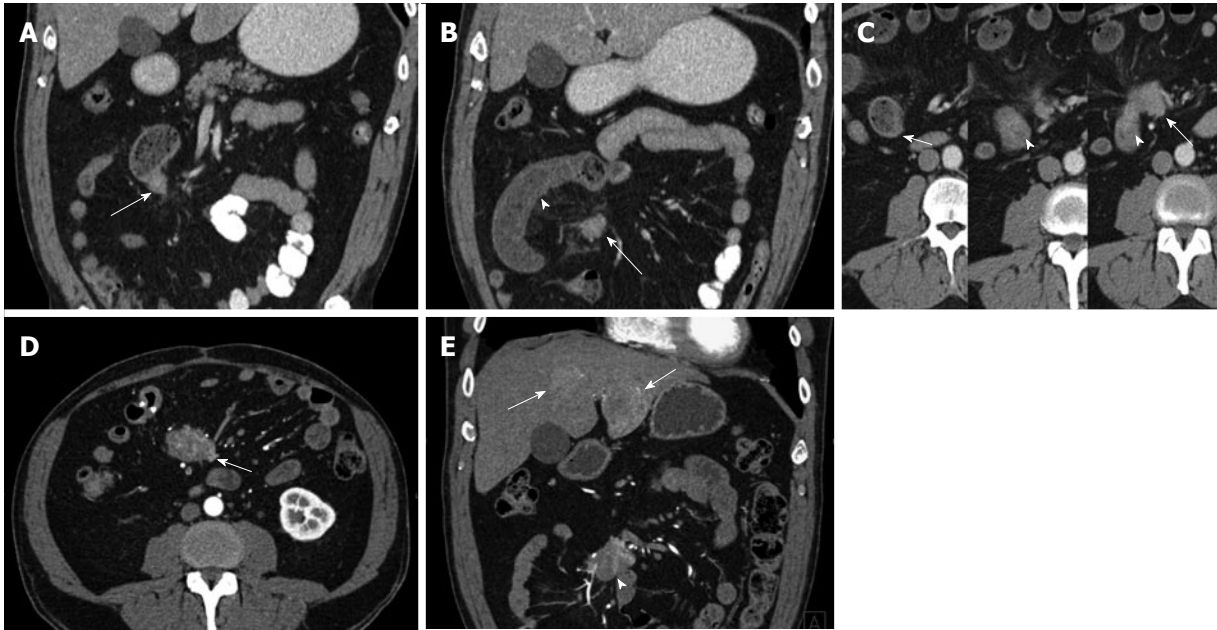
Ileal Carcinoid. A 53-year-old male with stage IV ileal carcinoid tumor, who presented acutely with small bowel obstruction and a history of several months of weight loss, crampy abdominal pain and distention. The patient underwent exploratory laparotomy with surgical resection of an ileal mass (biopsy-proven carcinoid) with primary anastomosis. A large mesenteric mass involving the main superior mesenteric vein and bilateral liver metastases were not resectable. A: Coronal venous phase computed tomography (CT) image shows a hypervascular mass in the wall of a distal ileal loop (arrow) representing the primary carcinoid tumor; B: Coronal venous phase CT image slightly more anterior shows dilated small bowel (arrowhead) with mural thickening and hypoenhancement, compatible with small bowel obstruction and suggestive of hypoperfusion. A portion of a mesenteric nodal mass (arrow) representing regional metastatic disease is shown (arrow); C: Serial axial CT images from the venous phase acquisition; Left: a dilated small bowel loop proximal to the obstruction demonstrates normal bowel wall enhancement and thickness; Middle: Compare the wall thickness and enhancement of the bowel wall at the site of the primary tumor (circumferential mass, invading the mesentery on the left side, arrowhead); Right: The next slice shows the hyperenhancing bowel wall mass (arrowhead) directly abutting the mesenteric lymph nodal metastatic conglomerate mass (arrow); D: Axial arterial phase computed tomography angiography (CTA) image shows the hypervascular mesenteric mass (arrow) reflecting regional lymph node metastatic disease; E: Coronal arterial phase CTA image shows the hypervascular mesenteric mass (arrowhead) reflecting regional lymph node metastatic disease. Hypervascular liver metastases (arrows) are depicted.
